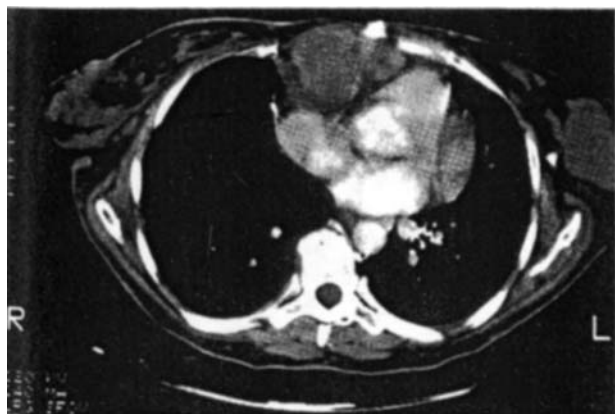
A chest computed tomography scan performed at a local hospital 4 months before the current admission to assess tumor progression. The scan demonstrates a somewhat heterogeneous mass in the anterior mediastinum, distorting the cardiac contour and invading the chest wall.
